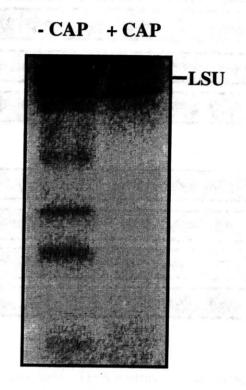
Inhibition of protein synthesis in the chloroplast. Cells grown in TAP medium were resuspended in no sulfate TAP medium in the absence (- CAP) and presence (+ CAP) of chloramphenical and labeled with carrier-free [35S]SO4² for 15 min. The total cell proteins were separated by SDS-PAGE with a 15% acrylamide gel which was exposed to a X-ray film. LSU represents RuBisCO large subunit.
